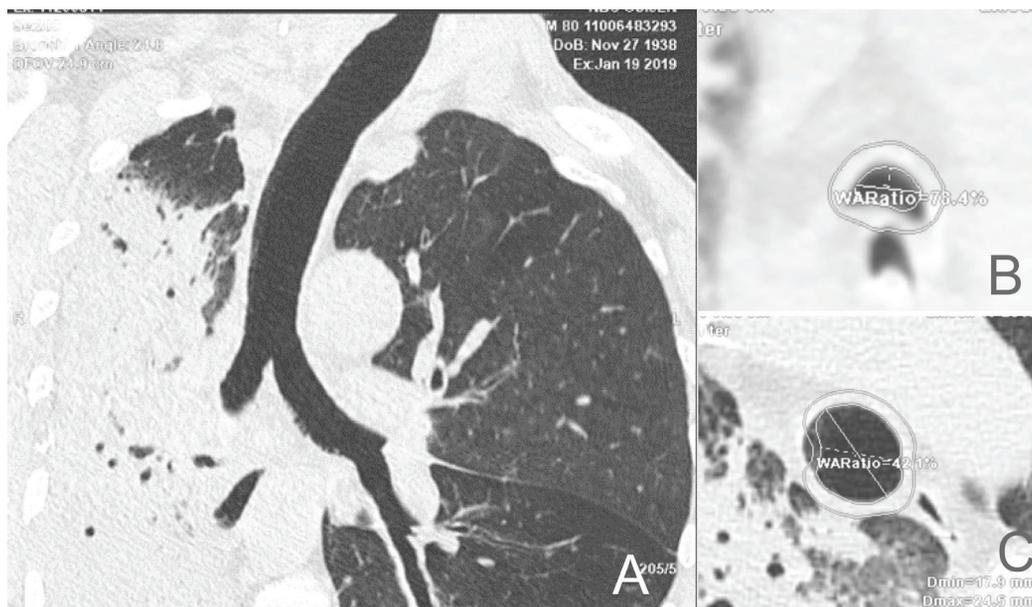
Coronal section of the multislice computed tomography scan in the patient with massive right-sided pneumonia, right-sided tracheal deviation (A); immediately below the bifurcation, both main bronchi are edematous and deformed with the membranous part pushed into the lumen of the bronchus (B); representation of the smallest and largest diameter of the trachea with an indication of the place where the membranous part of the trachea protrudes into the lumen (C).
